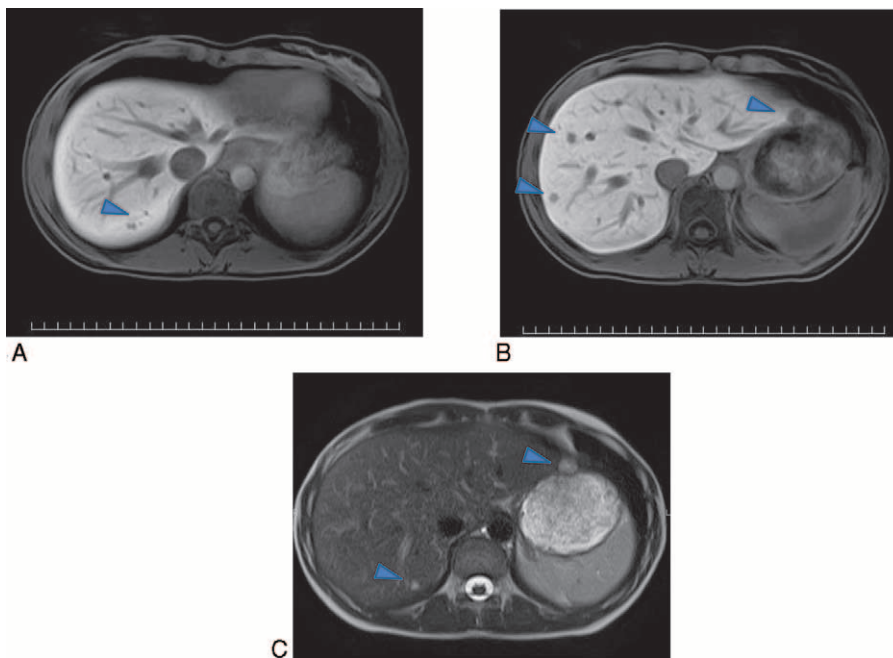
Magnetic resonance (MR) images from before the start of bevacizumab/paclitaxel/carboplatin therapy in 2009. T2-weighted MRI images of hepatocytes; low-intensity masses are visible in the same region shown in the computed tomography image; low-intensity masses in S7 (A) and low-intensity masses in S2 and S8 (B). T2-weighted image; high-intensity masses are visible in S7 and on the surface of the left lobe of the liver (C). These imaging results indicate liver metastasis of breast cancer (arrows indicate lesions).
